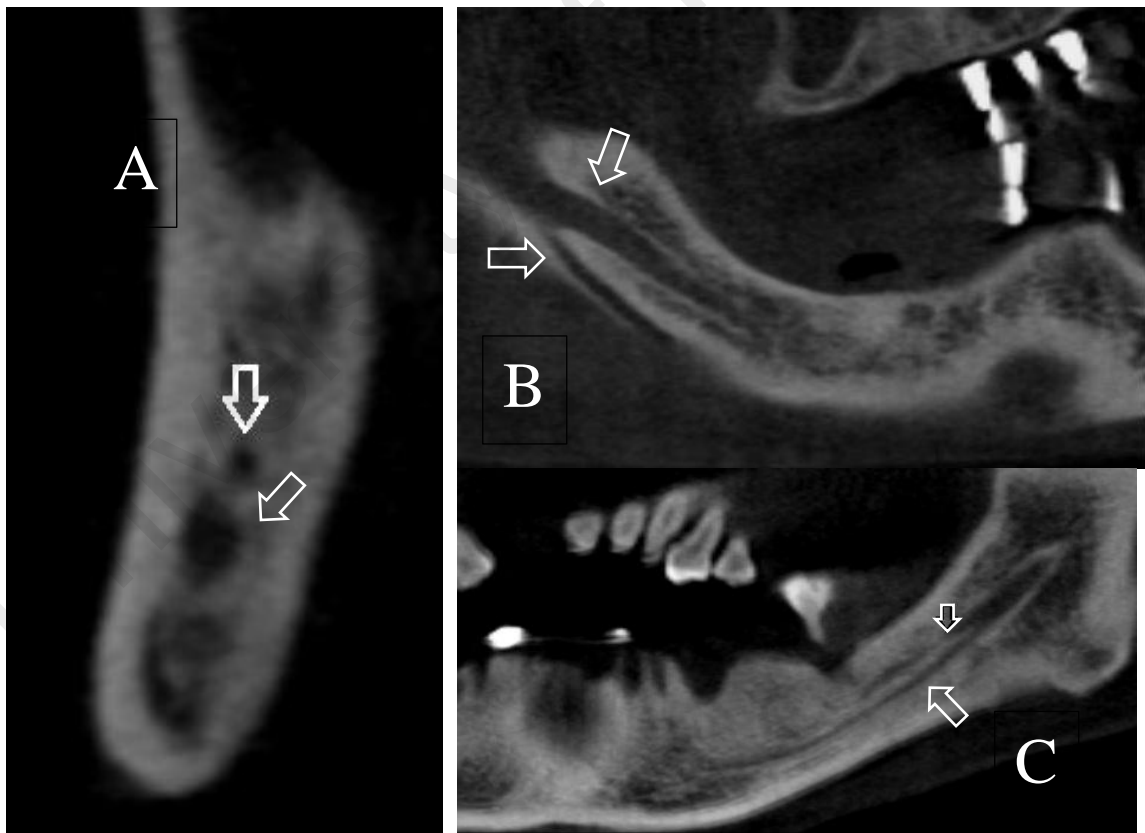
Bifid mandibular canal (White arrow) – Sagittal view (A) and panoramic view (B and C) of CBCT image improved with SimPlant software.
